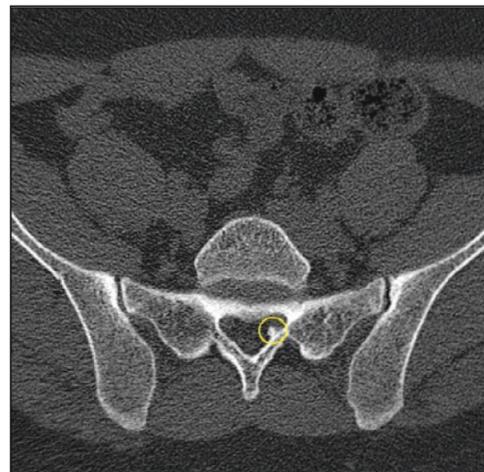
Lumbar computed tomography; osteoma starting from L5 level to S1 level, narrowing the left neural foramen and spinal canal.
